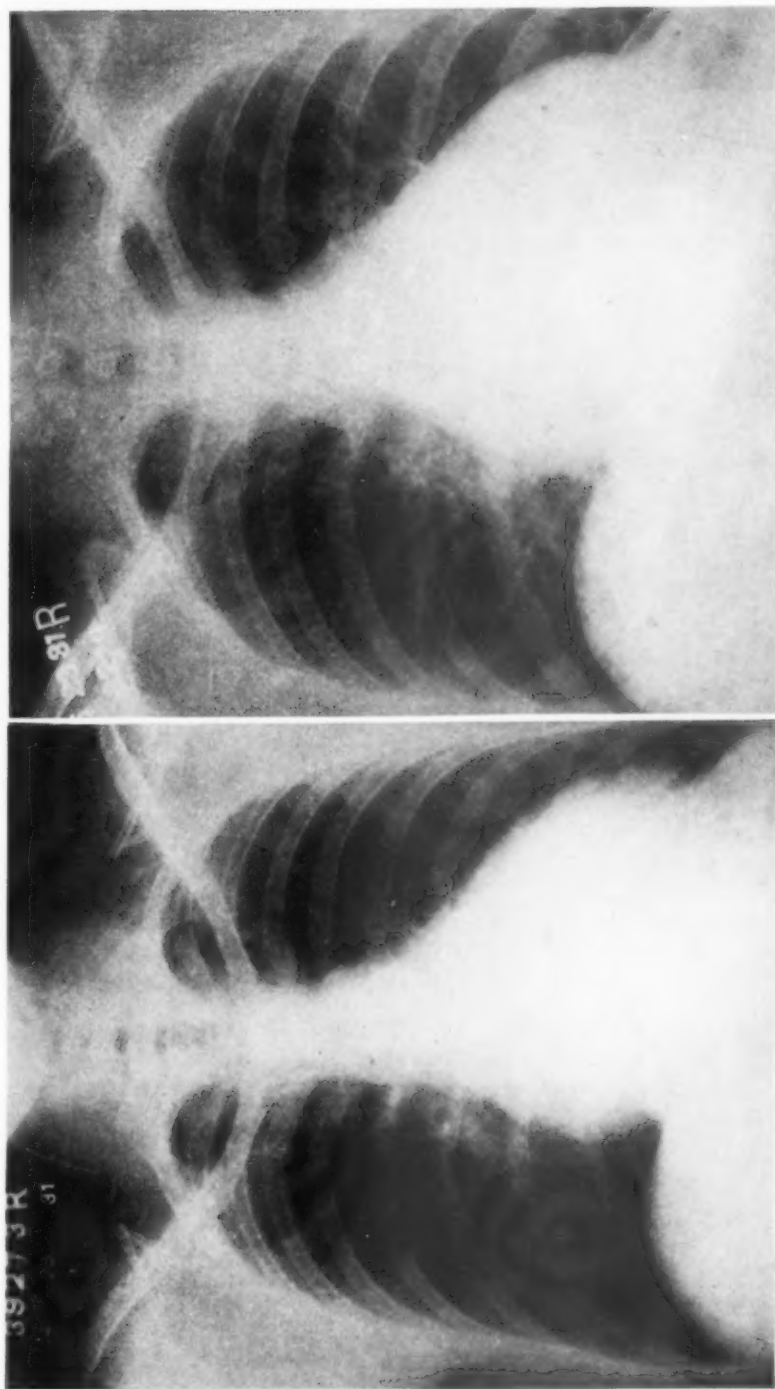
a. Roentgenogram of chest, taken two months after the onset of symptoms, indicates a generalized cardiac enlargement.
